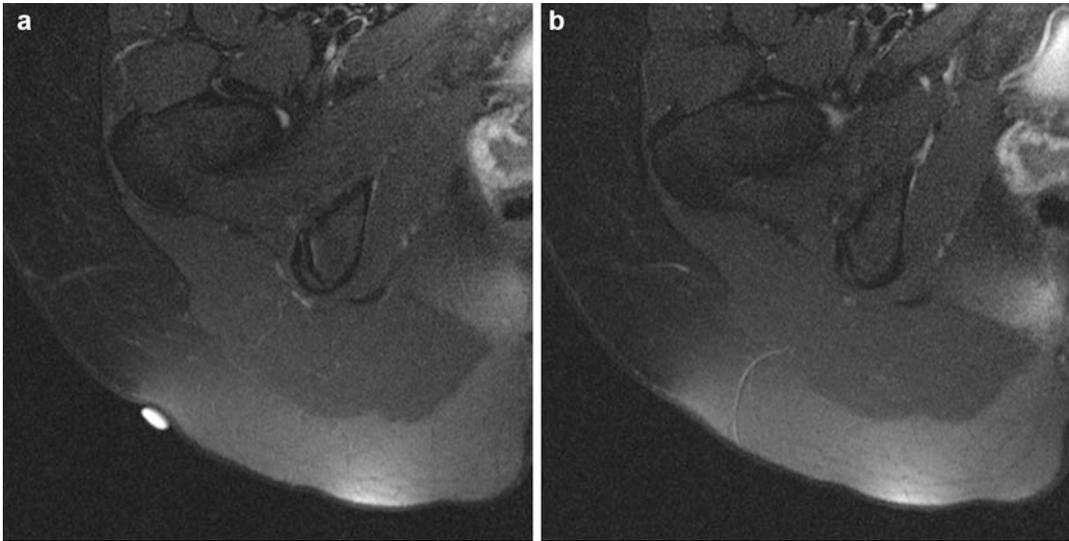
Sequence of magnetic resonance imaging of a patient in an area with a cellulite depression. The first slice (a) shows a skin marker identifying the cellulite
